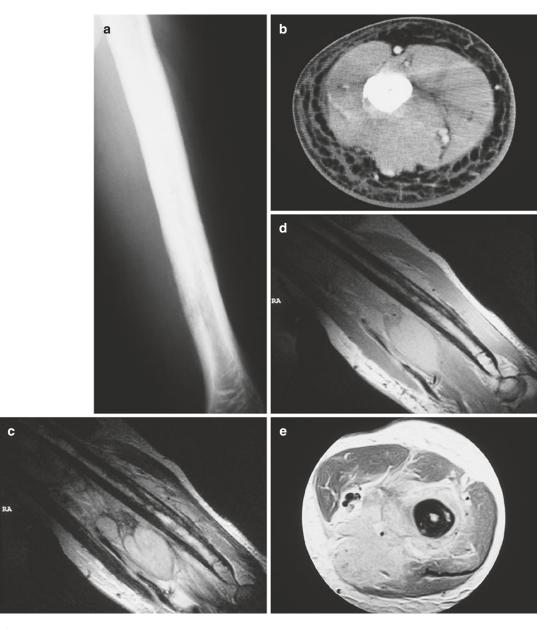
(a–e) A 64-year-old man with a palpable soft tissue mass at the left upper arm (non-Hodgkin's lymphoma): (a) radiography of the left humerus; (b) CT scan after iodinated contrast injection; (c, d) sagittal spin-echo T1- and T2-weighted MR images; (e) axial spin-echo T1-weighted MR image after gadolinium contrast administration. The initial radiographic examination reveals a permeated aspect of the cortex of the left humerus of a lengthy area with linear and irregular periosteal abnormalities (a). Contrast-enhanced CT scan shows a diffuse iso-attenuating infiltrating mass, whereas the borders of the lesion cannot be distinguished from the adjacent
